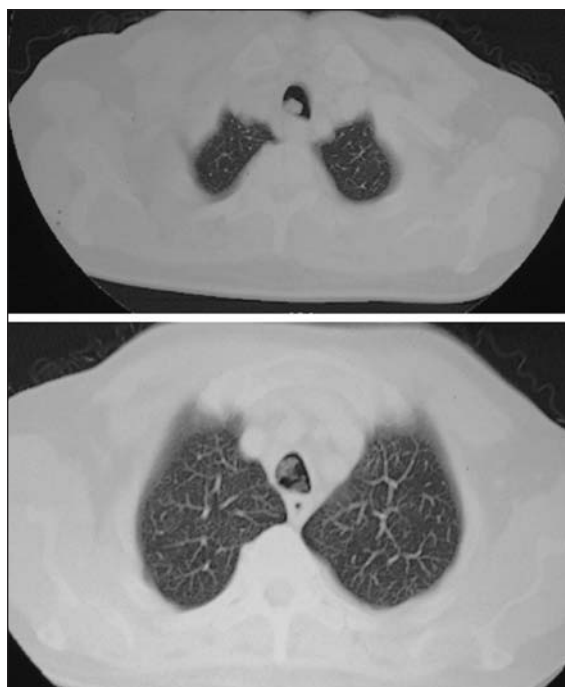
Axial CT slices demonstrate tracheal papillomas attached to the tracheal posterior and lateral walls.
